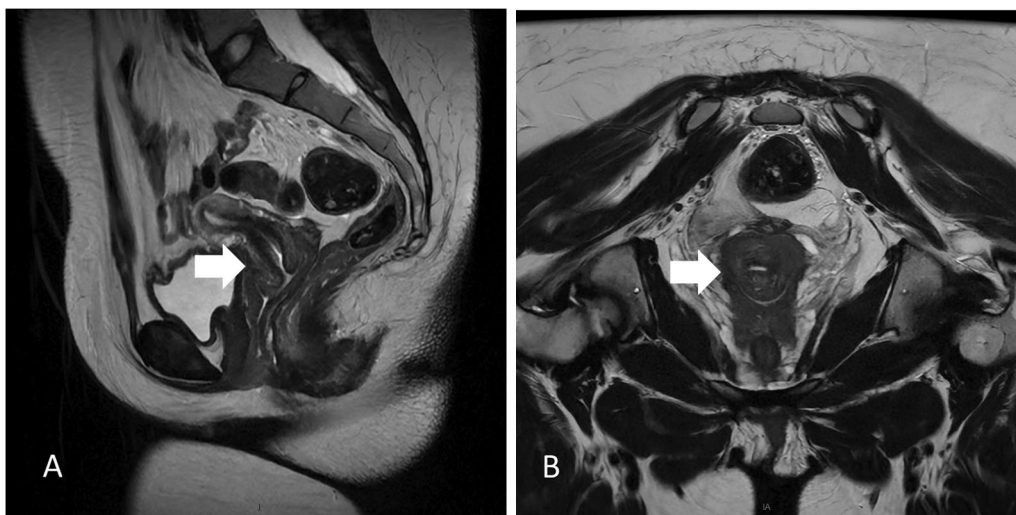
T2-weighted MR images showing regression of the swelling and edema of the uterine cervix on (A) sagittal and (B) transverse imaging (white arrows)
